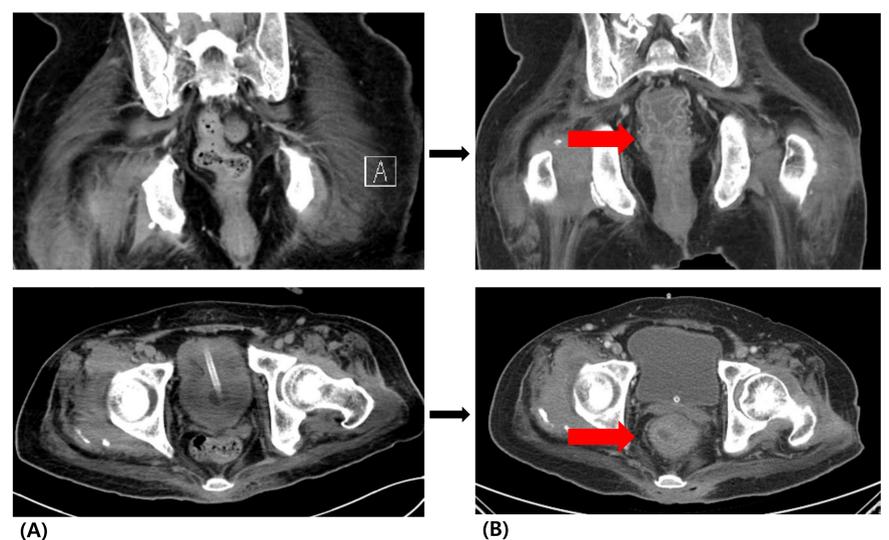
Abdominopelvic CT Images
